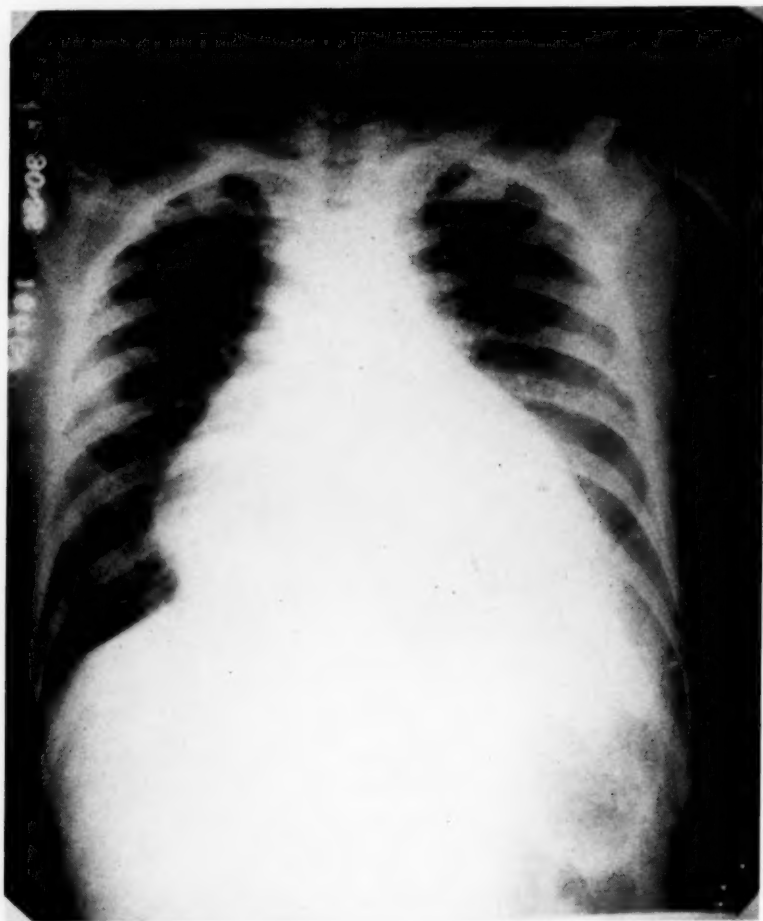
Roentgenogram showing pericardial effusion. Marked clearing of the left chest has occurred (December 30, 1936).
